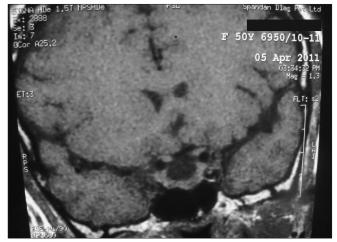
T1-weighted image of MRI brain (coronal view) shows large sella with pituitary enlargement
